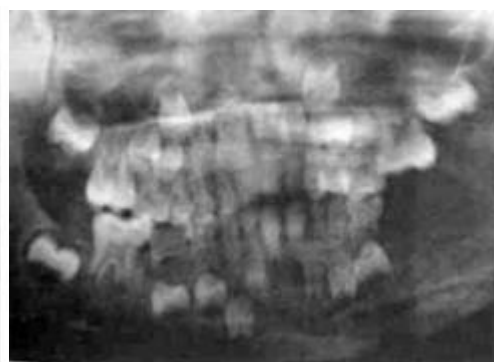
Orthopantomogram of a patient with of left lower jaw odontogenic osteomyelitis (destructive form) of the mandible after 9 months of treatment
